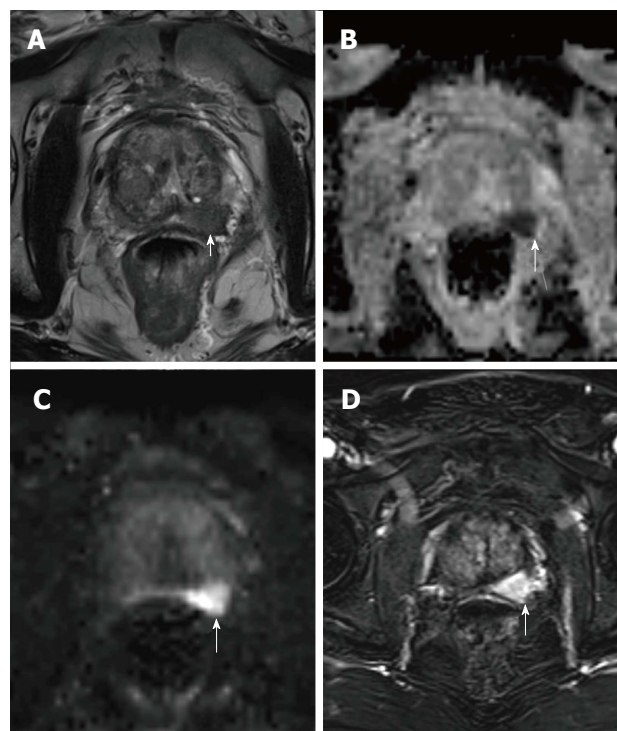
An 82-year-old patient with PIRADS 5 lesion in the basal left peripheral zone showing hypointensity (white arrows) in T2-weighted image (A), restriction of diffusion in apparent diffusion coefficient map (B) and diffusion-weighted magnetic resonance image (C), DCE shows significant early enhancement of the suspicious area (D). MRI-guided transrectal ultrasound biopsy confirmed a clinically significant prostatic carcinoma (Gleason 5 + 4). DCE: Dynamic contrast enhancement; MRI: Magnetic resonance imaging.
